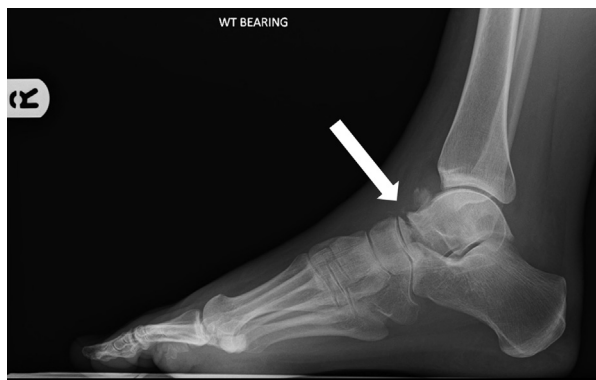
Lateral plain, weight-bearing radiograph of the right foot and ankle showing an ill-defined osseous body anterosuperior to the talus with a displaced fracture through the anterior aspect of the talus (arrow). There is also bony resorption and callus formation at the fracture margin. WT = weight.
